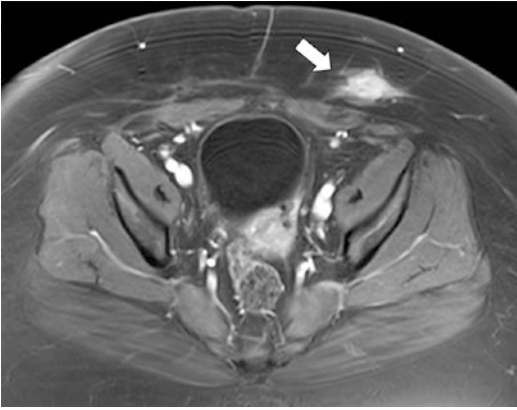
Gadolinium-enhanced T1-weighted, fat-suppressed axial image through the lesion (arrow) demonstrates enhancement. Collectively, the findings are compatible with endometriosis deposition within the operative incision site in the abdominal wall
